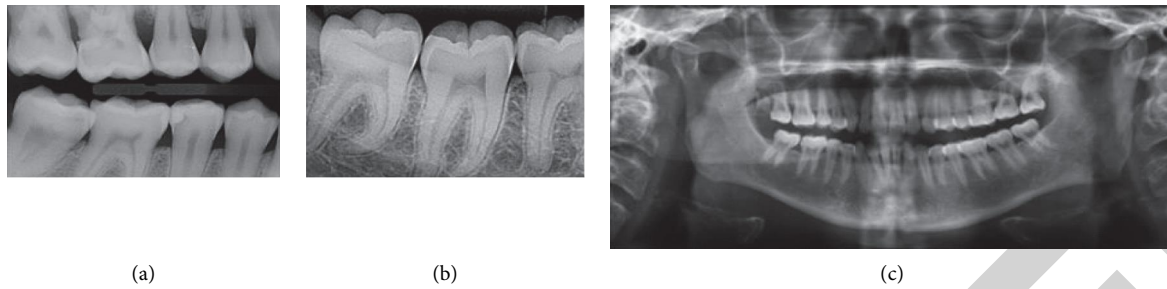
Types of dental imaging. (a) Bitewing X-ray. (b) Periapical X-ray. (c) Orthopantomogram X-ray.
